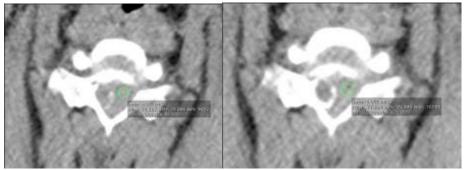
Root neoplasia: CT transverse scan of a CT-myelography at level of T1-T2.
